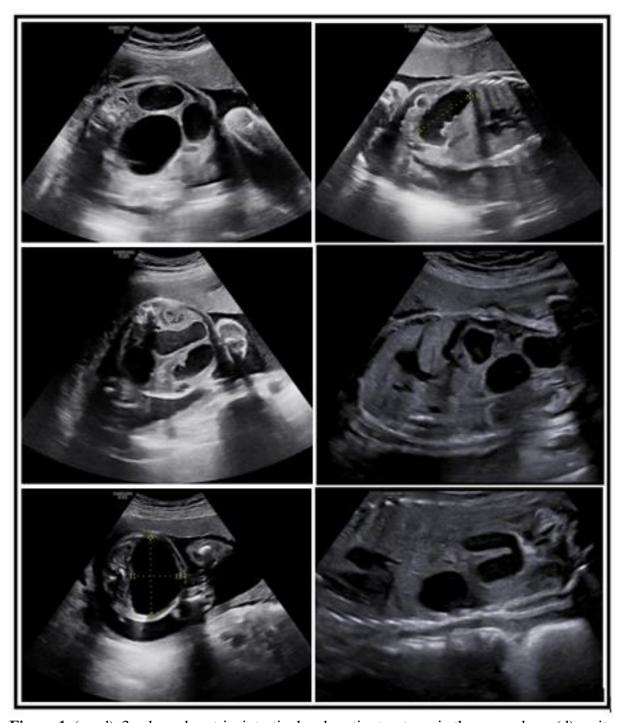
(a,c,d) 3 enlarged gastric, intestinal and cystic structures in the same plane, (d) ascite and (b,e,f)) other views of dilated structures are seen in the ultrasonographic images.
